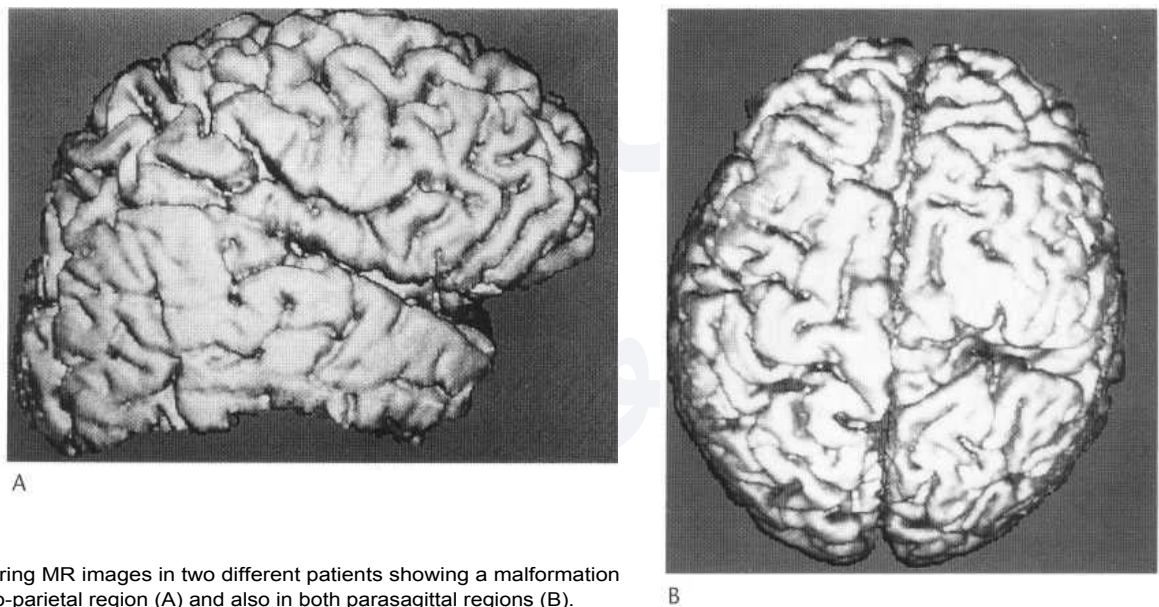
3D surface rendering MR images in two different patients showing a malformation of cortical development in fronto-parietal region (A) and also in both parasagittal regions (B).
